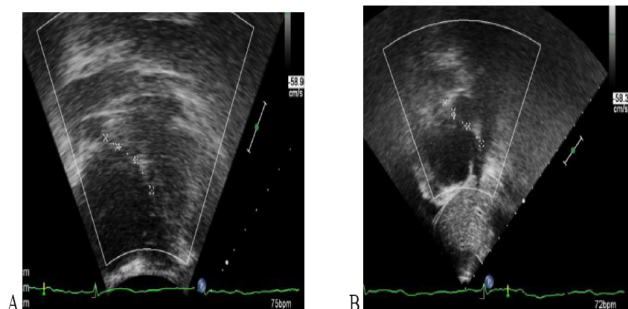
Subcostal 4-chamber (A) and short-axis (B) views of transthoracic two-dimensional echocardiographic measurement of ASD.
